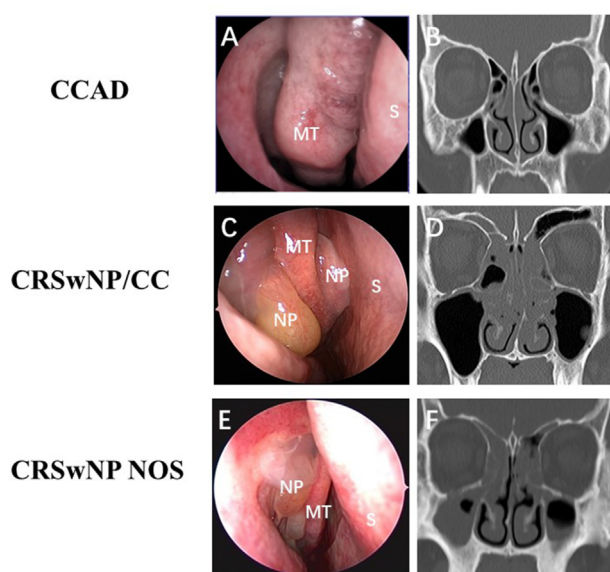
Representative CT and endoscopic images for CCAD (A, B), CRSwNP/CC (C, D), and CRSwNP NOS (E, F) before surgery. MT = middle turbinate, S = septum, NP = nasal polyps
